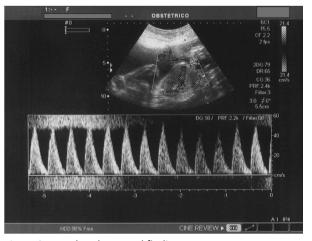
Doppler ultrasound findings.
